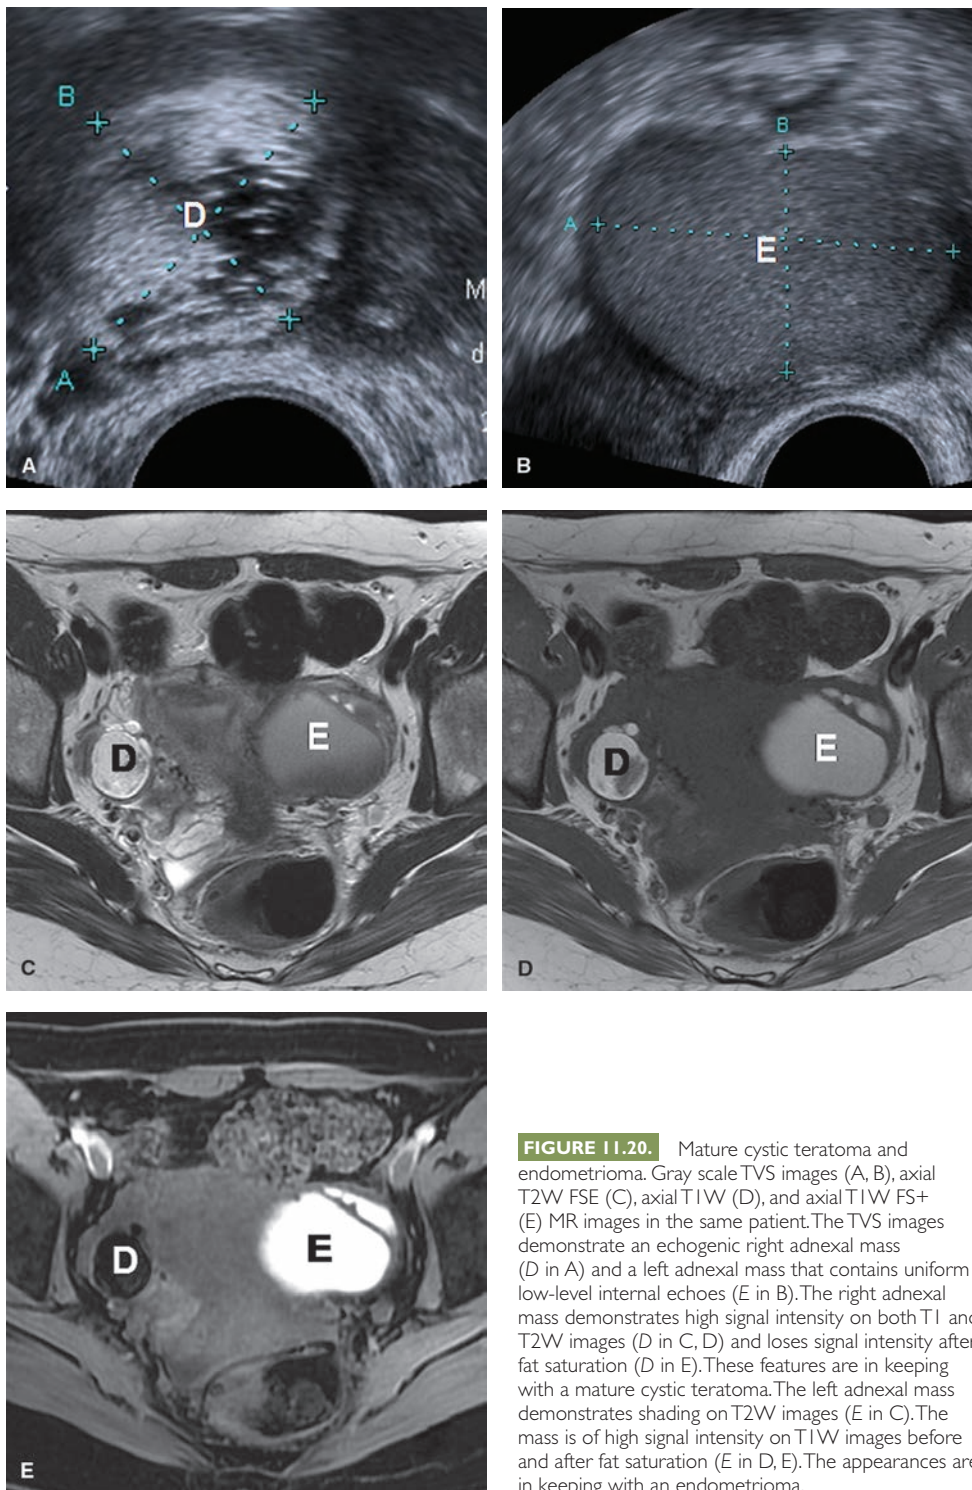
Mature cystic teratoma and endometrioma. Gray scale TVS images (A, B), axial T2W FSE (C), axial T1W (D), and axial T1W FS+ (E) MR images in the same patient. The TVS images demonstrate an echogenic right adnexal mass (D in A) and a left adnexal mass that contains uniform low-level internal echoes (E in B). The right adnexal mass demonstrates high signal intensity on both T1 and T2W images (D in C, D) and loses signal intensity after fat saturation (D in E). These features are in keeping with a mature cystic teratoma. The left adnexal mass demonstrates shading on T2W images (E in C). The mass is of high signal intensity on T1W images before and after fat saturation (E in D, E). The appearances are in keeping with an endometrioma.
